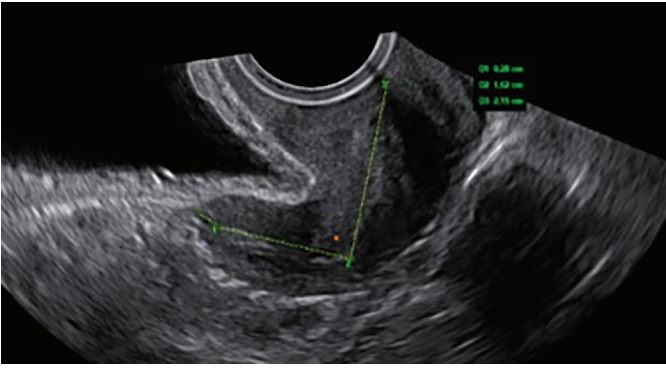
2D ultrasound view of a hypoplastic uterus. The total uterine length is 4.05 cm, significantly smaller than the normal length of 6 cm.
